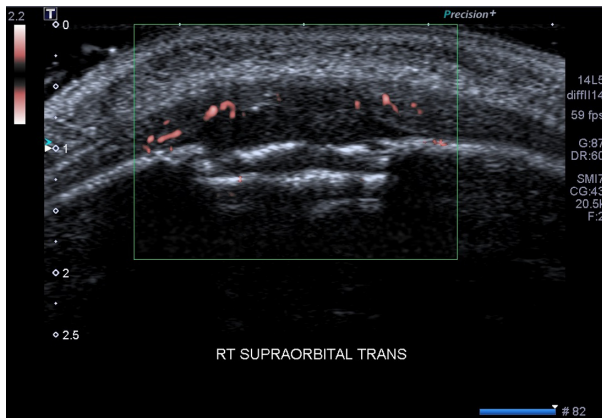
Transverse ultrasound image using superb microvascular imaging (SMI) demonstrating some periosteal hyperaemia.
